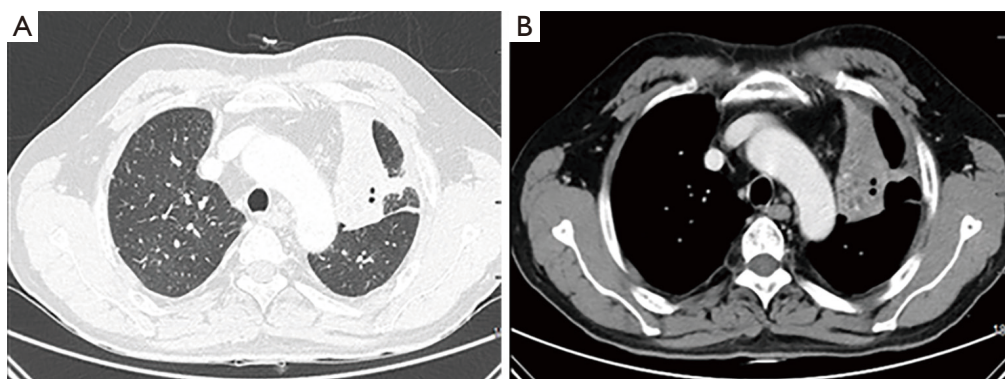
The patient repeated chest CT after neoadjuvant treatment. (A) Lung window in CT scan. (B) Mediastina window in CT scan.
